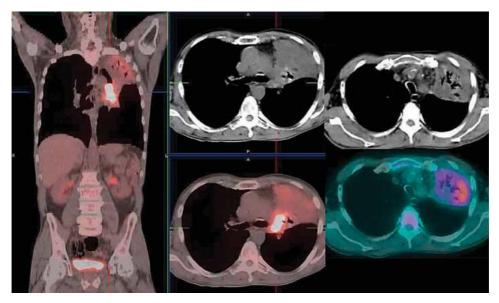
Differentiating atelectasis (non-FDG-avid) from vital tumor (FDG-avid) and obtructive pneumonitis (non- or only mild FDA-avid) by FDG-PET. This is especially important for patients with functionally inoperable primary tumors before external beam radiation therapy.
